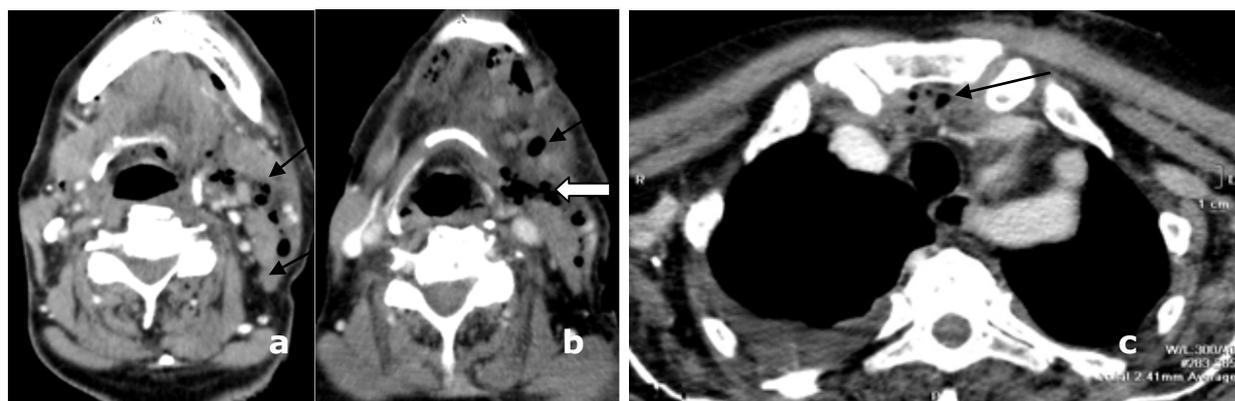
Phlegmon and abscesses of the submandibular region and the carotid space Postcontrast axial CT view, multiple abscesses with gas inclusions in the left submandibular region (black arrow) and an obliteration of the subcutaneous fatty tissues (white arrow) after incision (a,b); process expansion into the superior part of the frontal mediastinum (c)
